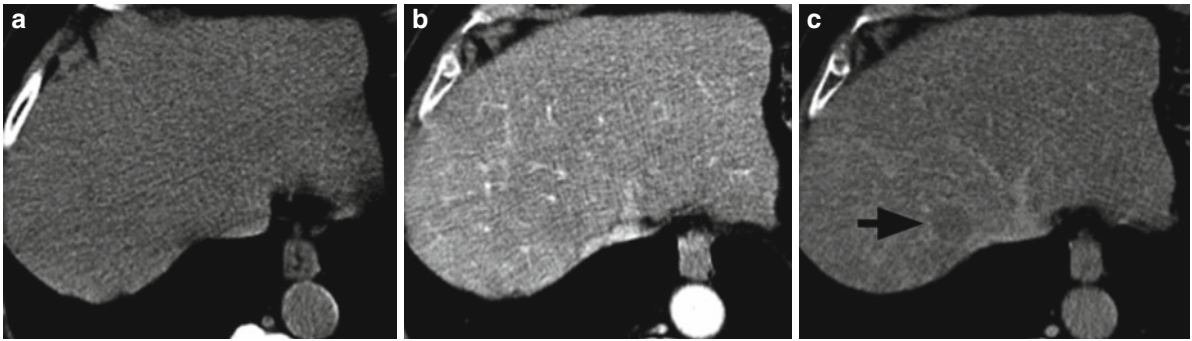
CT scans show a dysplastic nodule in a cirrhotic liver. On the (a) unenhanced and (b) hepatic arterial phase images, no definite lesion can be identified. (c) Corresponding image obtained during the delayed phase demonstrates
